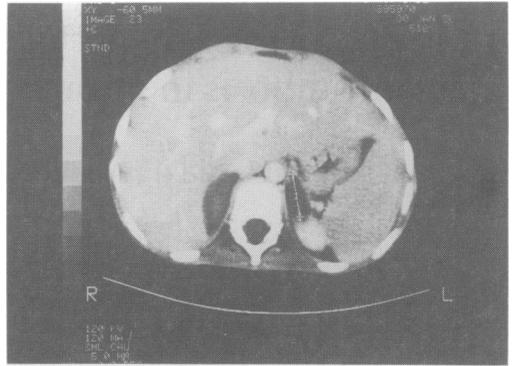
Contrast-enhanced CT scan of the adrenals showing bilaterally enlarged adrenals of low intensity with no enhancement.
